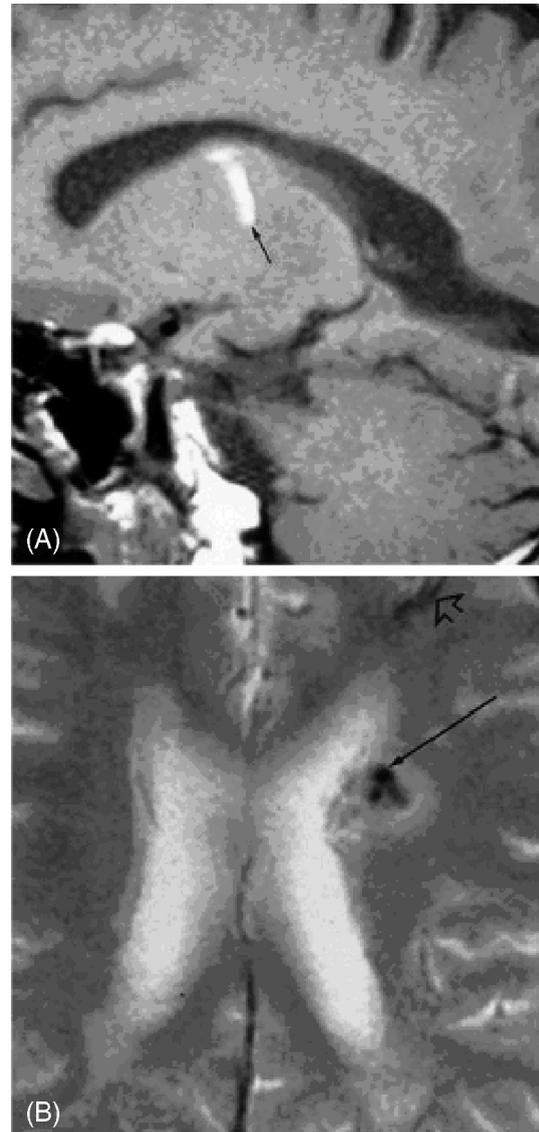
(A) T1 sagittal magnetic resonance (MR) to the left of midline shows linear high signal consistent with blood products corresponding (arrow) with the abnormalities seen on axial imaging. On the immediately adjacent lateral slice (not shown) an area of low signal around this was more evidence consistent with infarction. (B) Gradient echo axial MR shows decreased signal consistent with hemosiderin lying centrally (arrow) within an area of increased signal (arrow-head) consistent with infarction. Note also on the MR images the area of previous hemorrhage in the left frontal cortex (open arrow) mild atrophy and some leukoariosis. There was also evidence of an old microhemorrhage in the right thalamus (not shown) and a further old cortical hemorrhage in the right occipital region (not shown) (Wardlaw et al., 2001).
